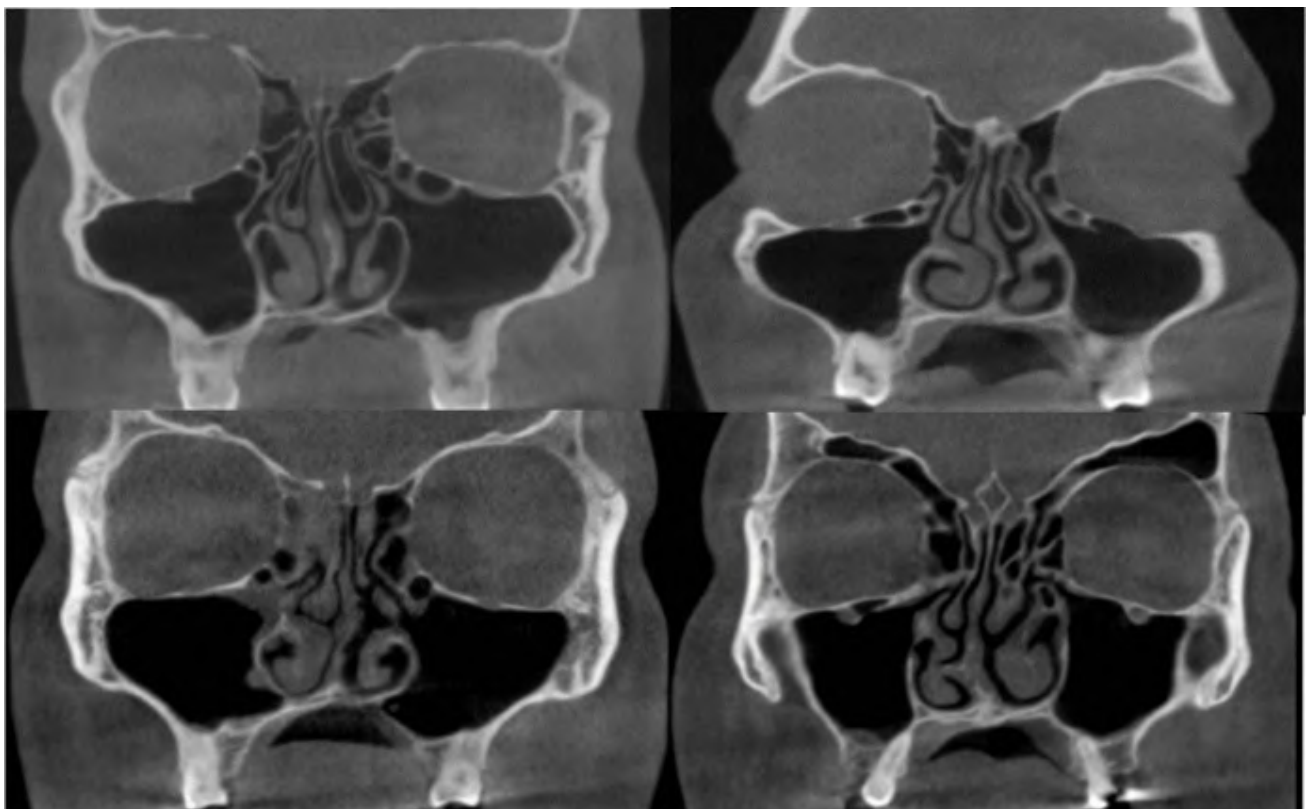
Variable presentation of Haller cells in our study on CBCT.
